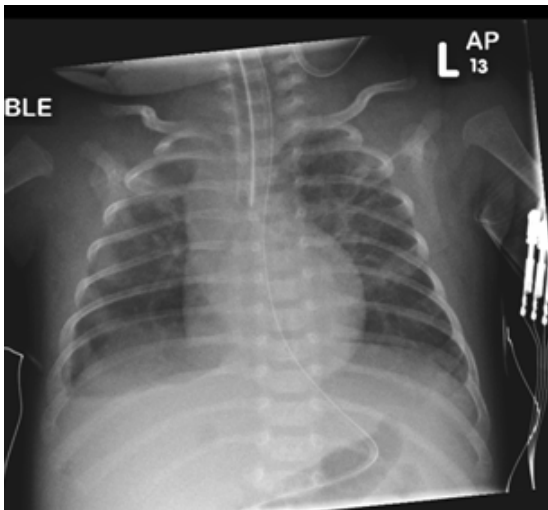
Postoperative chest x-ray after right-sided eventration repair for the same patient as in Figure 45.7.
